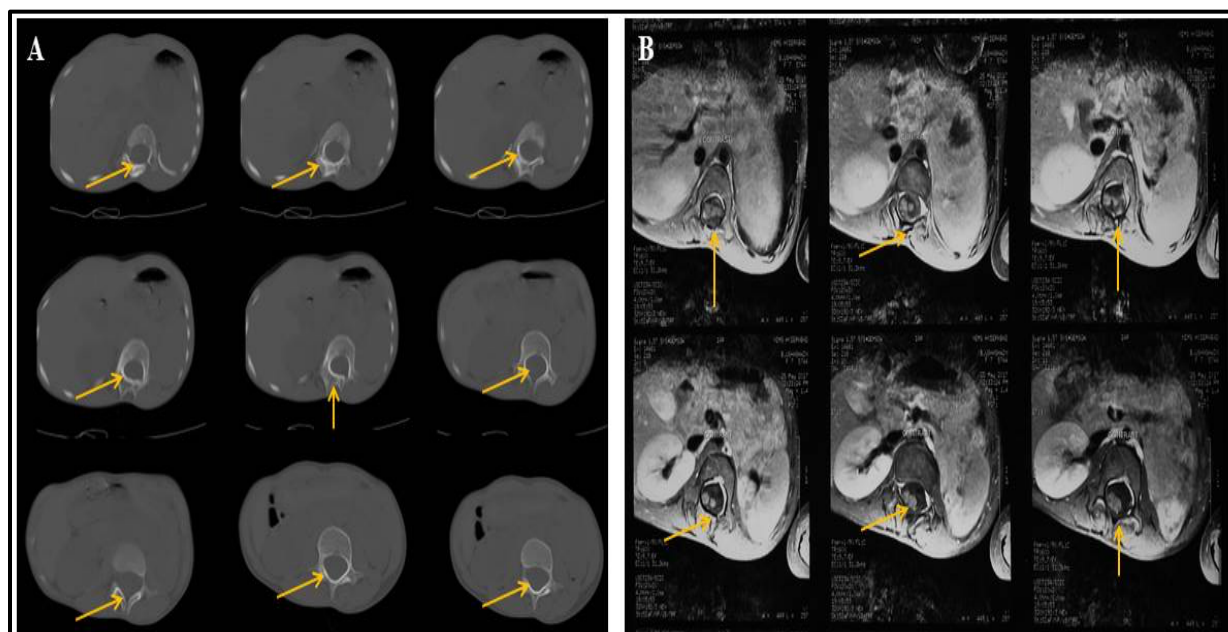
A) Axial CT showing bifid spine with no bony septum, B) Axial MRI showing diplomyelia with no epidermoid.
